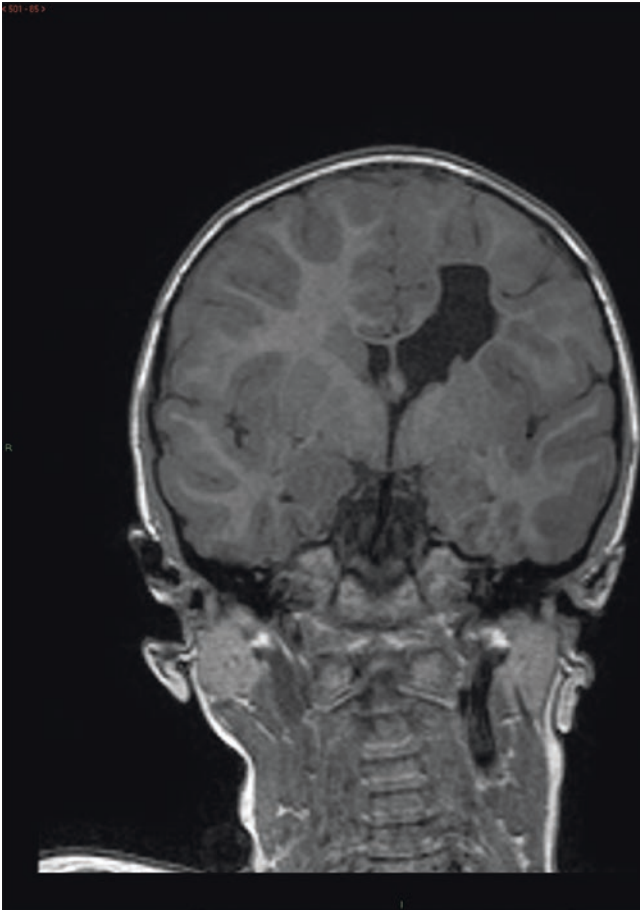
Left frontal porencephalic cyst. Coronal T1-weighted MR image shows a CSF space communicating directly with the left lateral ventricle
